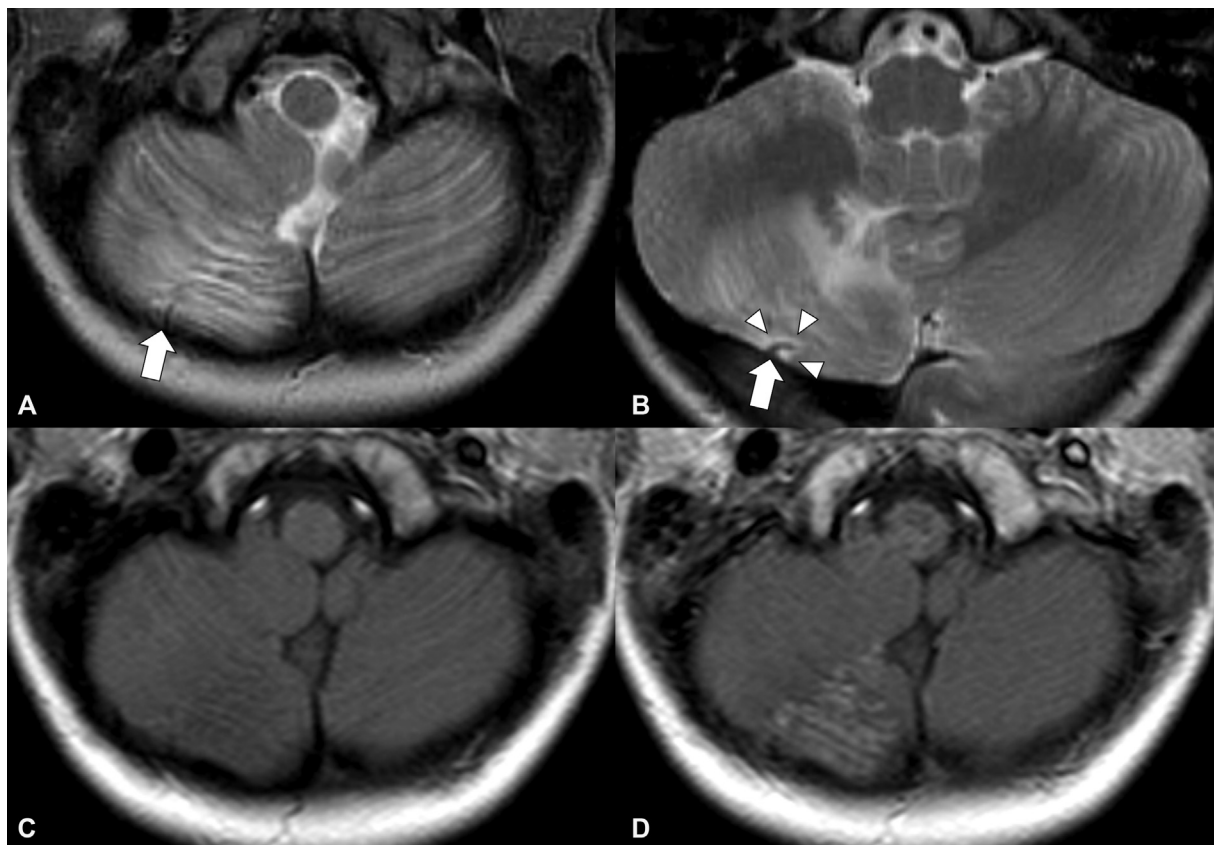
A 7-year-old boy with a right cerebellar tuber. (A, B) Fan-shaped tuber shows hyperintensity on T2-weighted image (T2WI). Contour deformity due to retraction change is present (arrow heads). There is also a prominent flow void coursing adjacent to the tuber, defined as an associated vascular anomaly (arrow). (C) Tuber shows slight hypointensity on T1-weighted image (T1WI). (D) Contrast enhancement is present on contrast-enhanced T1WI, showing a striped pattern with a high and low intensity, “zebra-like appearance.”
